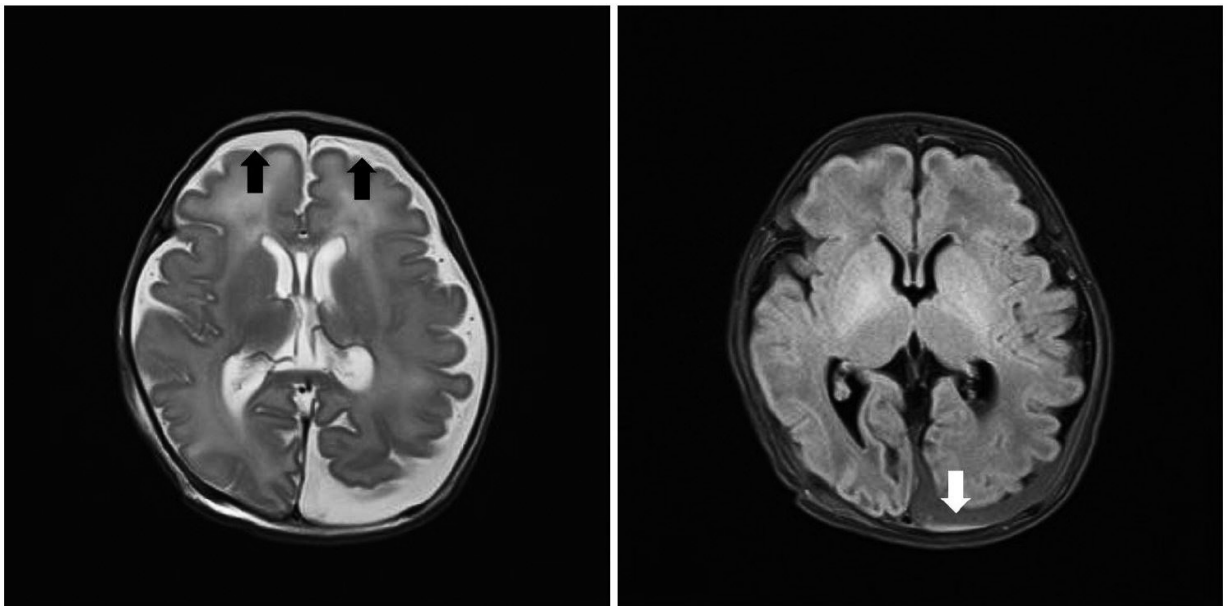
MRI of the brain reveals enlarged subarachnoid spaces without ventricular enlargement (black arrows) and fluid in bilateral subdural spaces that more in left parietooccipital region (white arrow).
